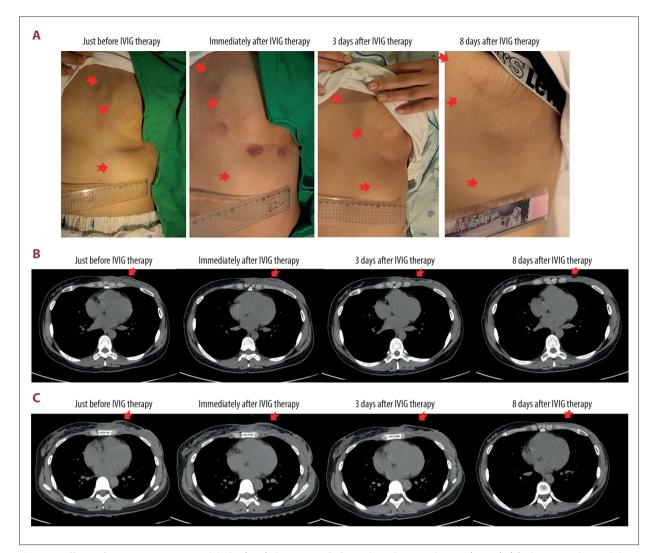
Effects of intravenous immunoglobulin (IVIG) therapy in Pfeifer-Weber-Christian disease (PWCD). (A) Change in skin nodules by IVIG therapy. Multiple crops of palpable masses on the left anterior chest decreased in size after IVIG therapy (before, immediately after, 3 days after, and 8 weeks after IVIG therapy). Chest deformities remained. The red arrows indicate masses. (B, C) Changes in computed tomography (CT) scan findings. The initial computed tomography (CT) scan findings were diffuse extensive infiltrative lesions involving the left anterior chest and abdominal wall, mainly involving the subcutaneous layer, with focal skin thickening, and probable lymphoma infiltrating subcutaneous fat was suggested with a probable diagnosis of cutaneous lymphoma as in the previous diagnoses in the other hospitals. On CT scan, the improvement in infiltrative multiple lesions on the left anterior chest began after 3 days. The lesions on the CT scan were much improved 8 weeks after IVIG therapy. Red arrows indicate masses. Figure B is the middle mass, and Figure C is the lower mass in Figure A.
